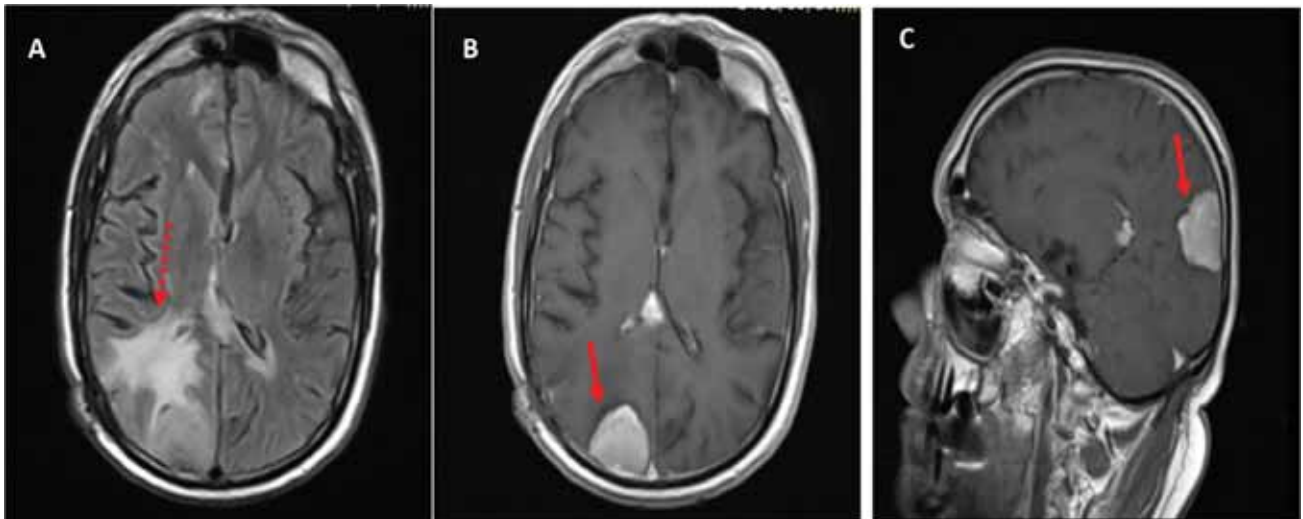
This figure encompasses A) A FLAIR sequence on the transverse plane, revealing the lesion and peritumoral edema (indicated by the round red arrow). 4B and 4C present the transverse and sagittal planes of the Gd-T1w sequence, showcasing a new 20mm enhancing lesion within the right parasagittal region of the posterior parieto-occipital lobe (highlighted by the red arrow), in addition to nodular enhancement within the previous tumor bed, suggestive of residual tumor.
